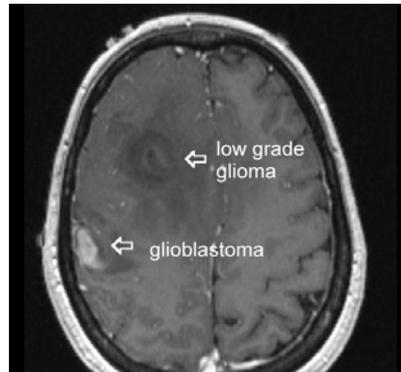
An MRI of a patient with two separate types of brain tumor, a low grade glioma in the right frontal lobe (which is very difficult to see) and a high grade glioma (Glioblastoma) in the right parietal lobe which shows more (gray white appearance) contrast enhancement [1]
